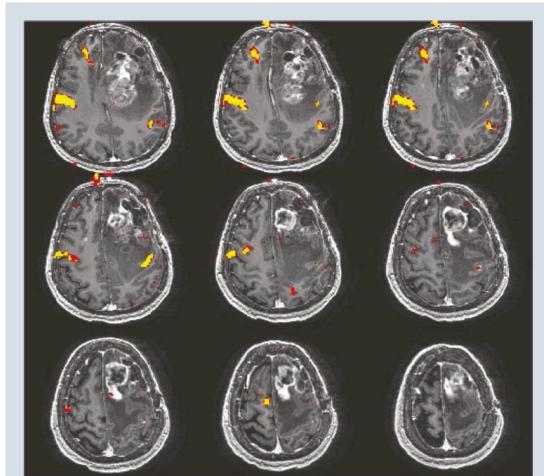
Left frontal glioblastoma. Notwithstanding the presence of motion artifact, prior surgery and abnormal tumor neovasculation the location of the ipsilateral motor gyrus is clearly depicted by functional MRI. The signal activation outside the brain is probably caused by motion artifact.
